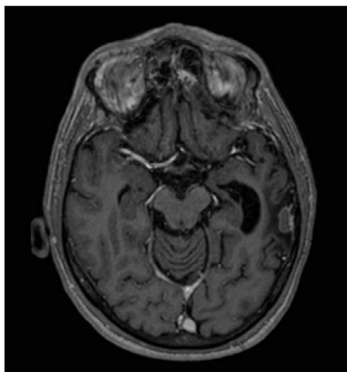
Posttreatment T1-weighted contrast-enhanced MRI. Expansive lesion centered on the left middle temporal gyrus presenting peripheral enhancement. Dimensions of the lesion: 1,9 x 0,8 x 1,5 cm. There are signs of perilesional encephalomalacia and gliosis.
